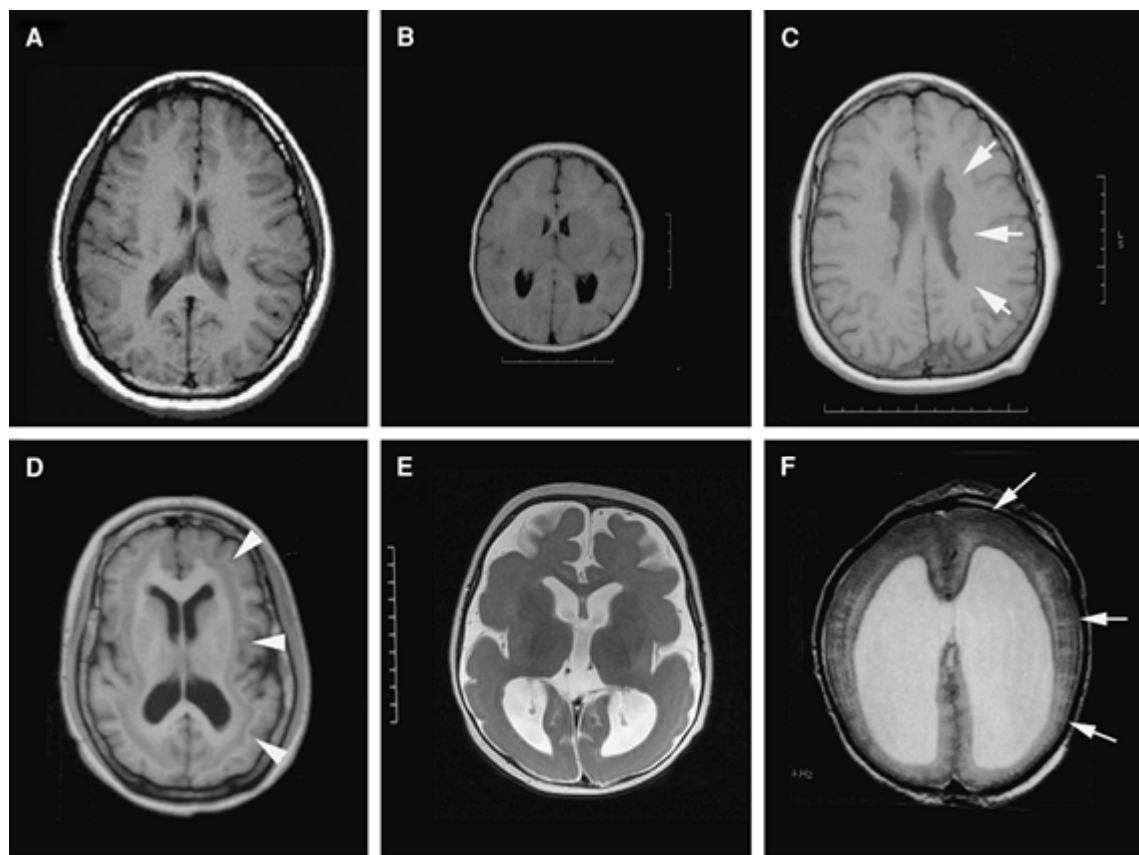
Genetically inherited malformations of cortical development. A: Axial T1-weighted MR image of a normal brain B: Microcephaly with simplified gyral pattern. The brain size is greater than two standard deviations below the norm. In microcephaly vera, the brain structures (cortical sulci and gyri, basal ganglia and fiber tracts) are normal in appearance but reduced in size. C: Periventricular
